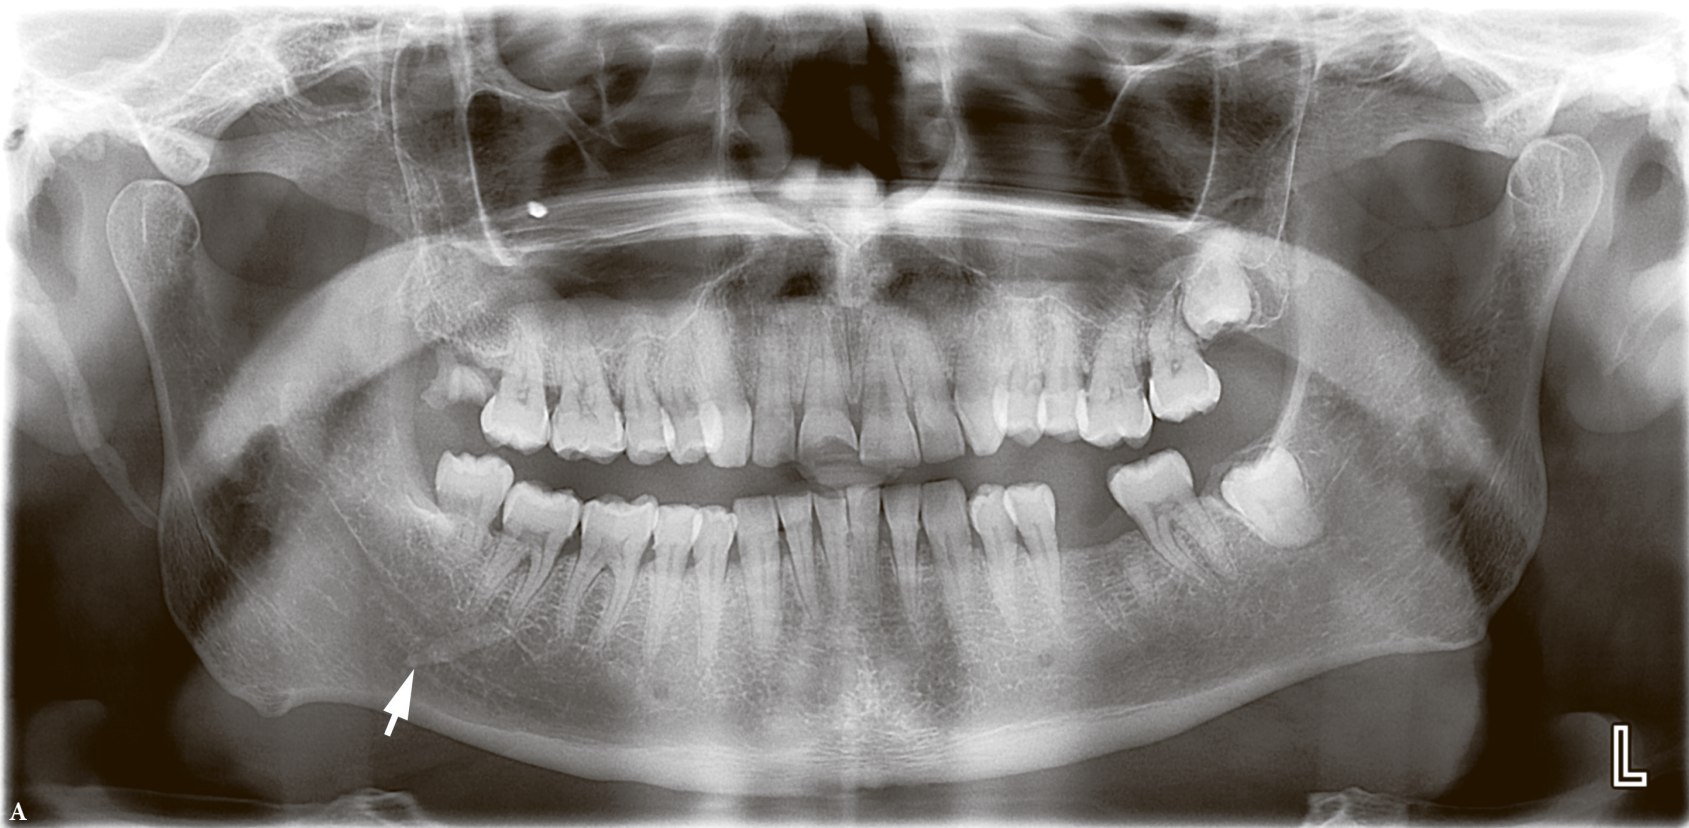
Case 5: The orthopantomograms of 41-year-old gentleman before (A) and after (B) sialolith removal. The sialolith (*arrow*) is visualized as elongated radiopaque lesion overlapping the right mandibular body in the projection of posterior part of Wharton's duct. Image B shows no evidence of sialolith. Time period between two images is 4 days. (Fig 5 continued on next page.)
